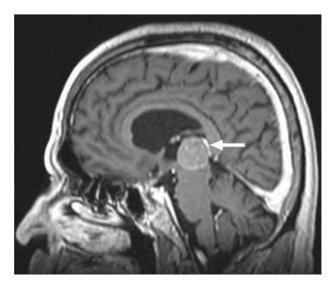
Repeated gadolinium-enhanced-MRI images performed just prior to the biopsy of the pineal mass (sagittal view), demonstrating that the tumor was increasing in size, starting to compress the nearby brain structures (arrow).
